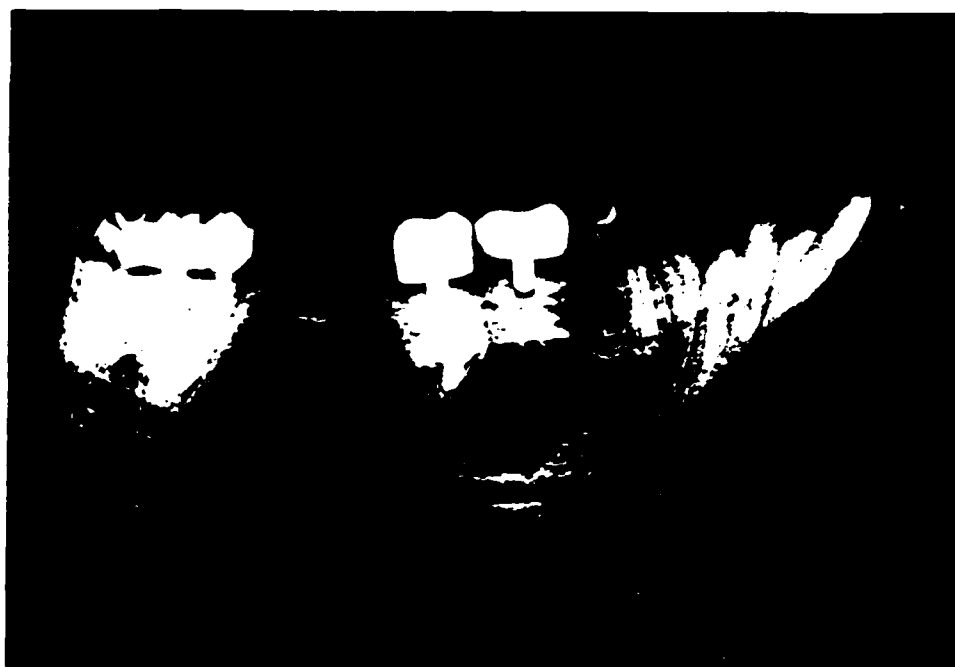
POST NECROPSY RADIOGRAPH OF A29 AND A30 IN BABOON 469
